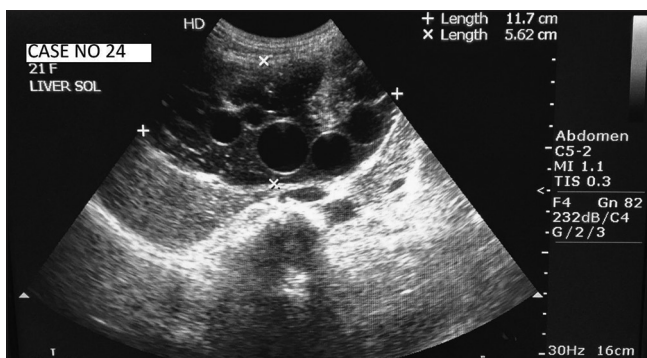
Ultrasonography: Hepatic hydatid lesion with daughter cyst
